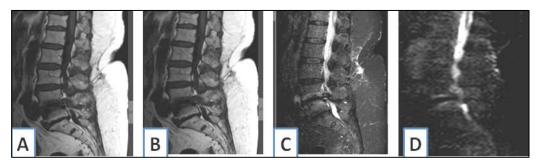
46 years old male presents with back pain. A: Sagittal T1 show L4-5 endplate hypo signal intensity. B: Sagittal T2 show L4-5 endplate hyper signal intensity. C: Sagittal STIR showsL4-5 endplate hyper signal intensity. D: Sagittal DWI show L4-5 questionable claw sign, the final diagnosis was Modic 1 degenerative changes.
